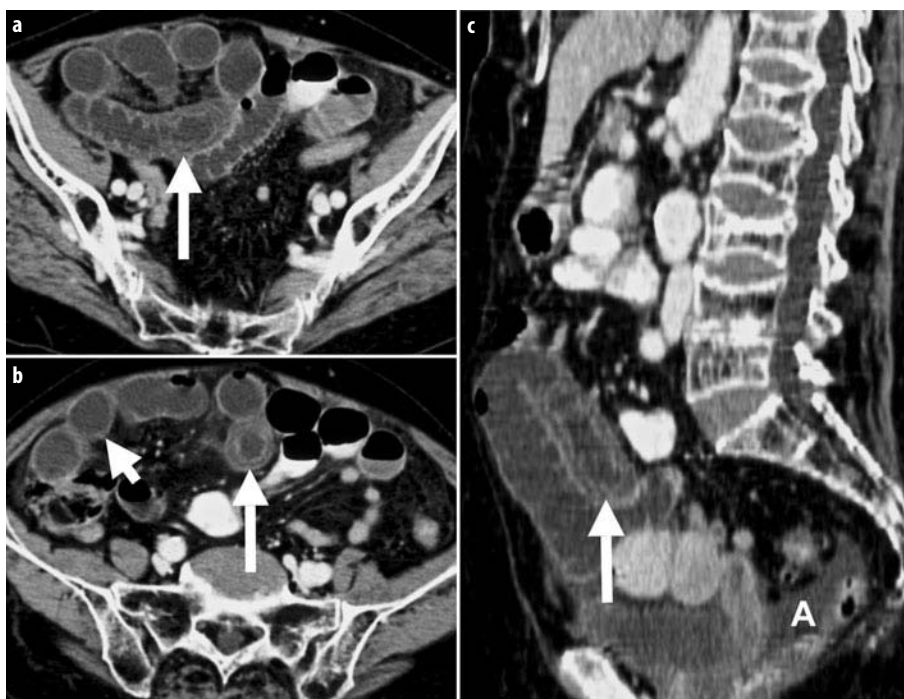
a-c. Strangulating small bowel obstruction due to an adhesive band that developed after cholecystectomy and appendectomy. Axial (a, b) and sagittal (c) views of multidetector CT show bowel wall thickening, enhancing bowel wall with submucosal edema, and/or hemorrhage giving a target sign (*long arrows*), indicating ischemia. Non-enhancement of the bowel wall of the jejunum (*short arrow*) corresponds to segmental infarction. A Ascites
